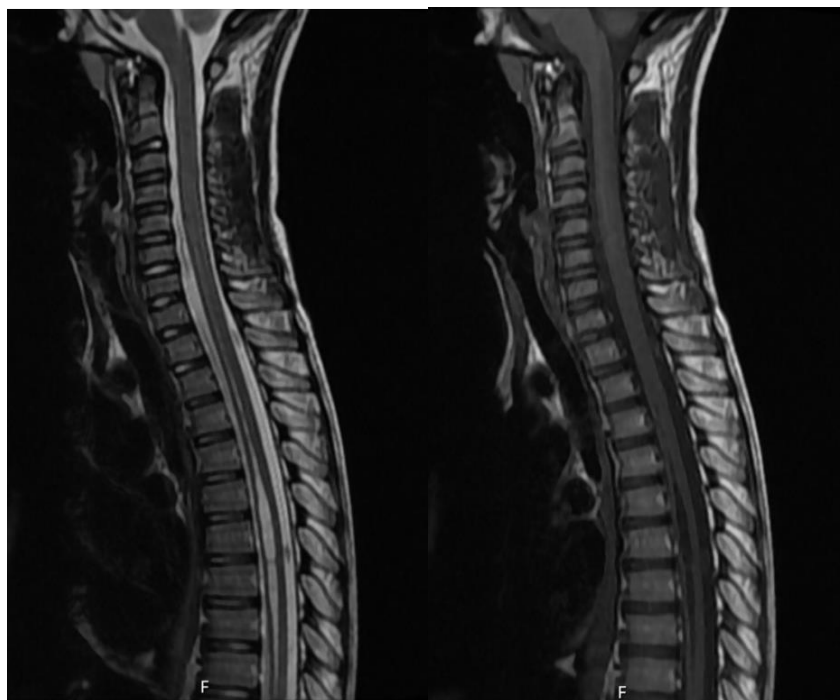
(a): MRI Spine Sagittal T2 FRFSE of thoracic syrinx; (b): Corresponding T1 Flair of thoracic syrinx.
